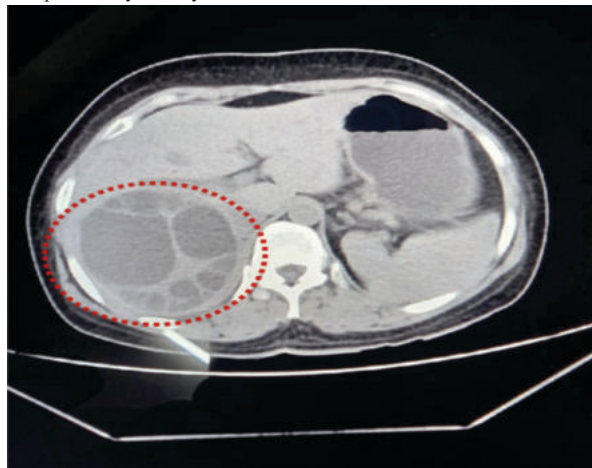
CT scan showing multiloculated cyst (Encircled in red) in right hepatic lobe
